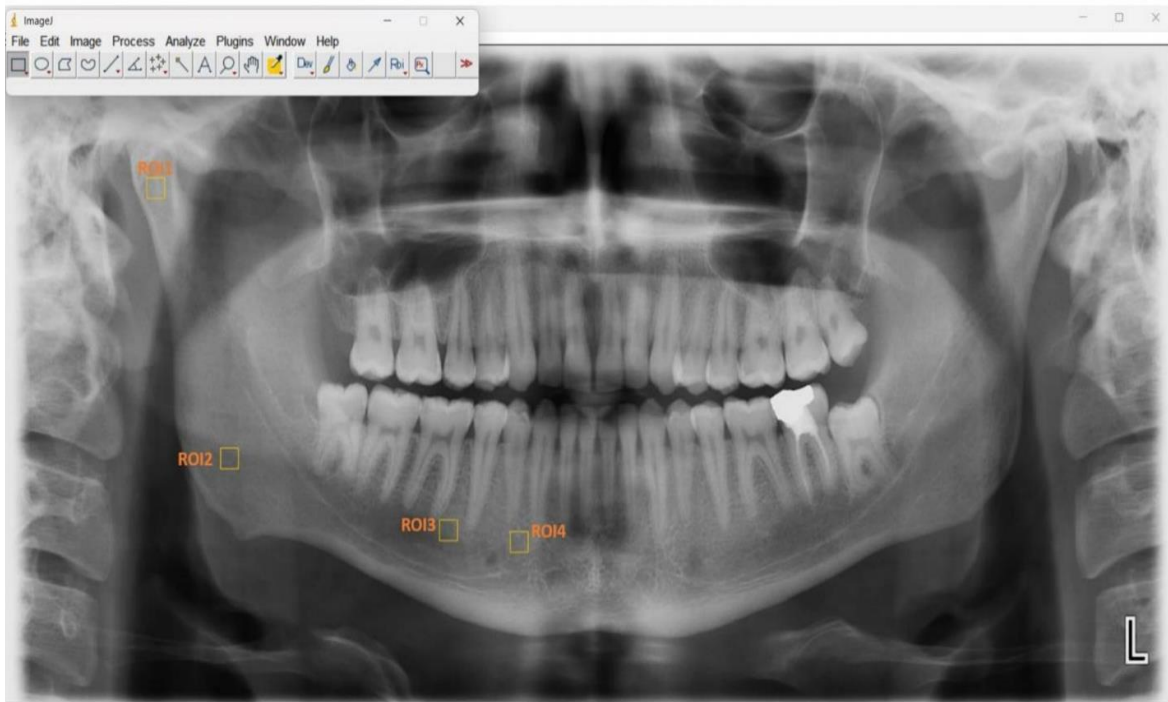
Selection of ROI in digital panoramic radiography with imagej
